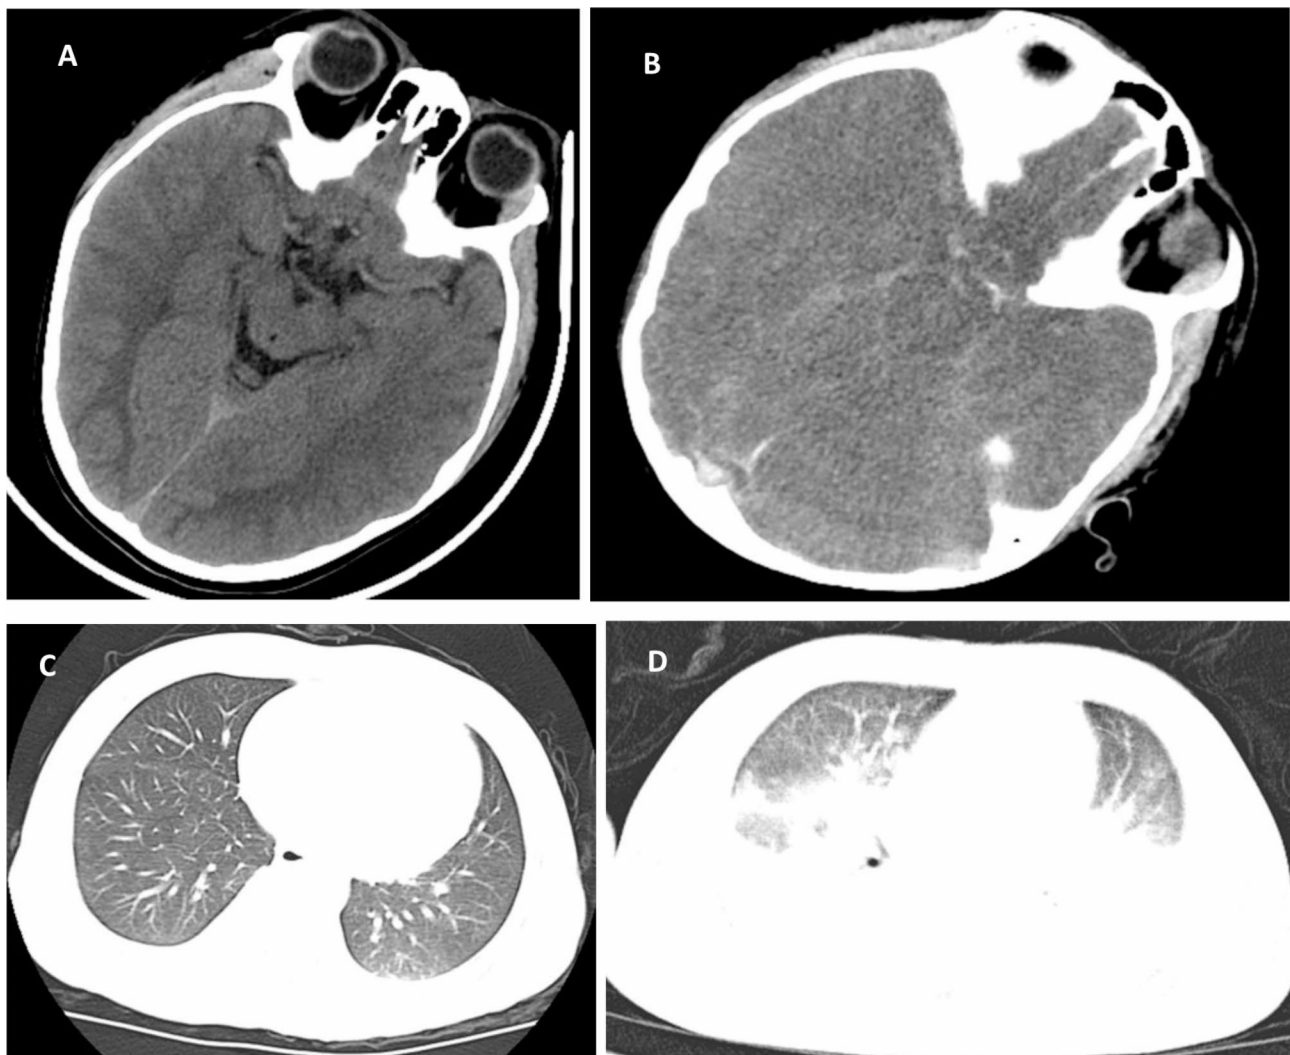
Head and chest imaging findings during the patient's treatment. On the day of admission, the child's CT scan of the brain and lungs showed no abnormalities (Image A, C); On the fourth day of admission, the child's CT scan of the brain revealed encephalocoele shrinkage, increased density, extensive brain edema, diffuse brain ischemic swelling with subarachnoid hemorrhage (Image B), and the lung CT scan showed pleural effusion and incomplete expansion of the lower lungs (Image D)
